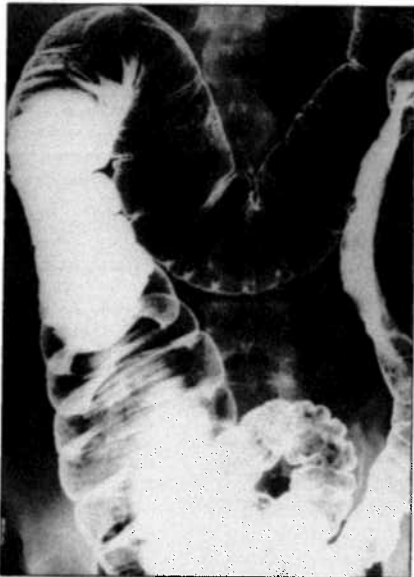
Abdominal radiograph in the supine position demonstrates an abrupt transition between the normal caliber and significantly narrowed abnormal appearing colonic segment in the splenic flexure. This abnormality also involves a large portion of the descending colon.
